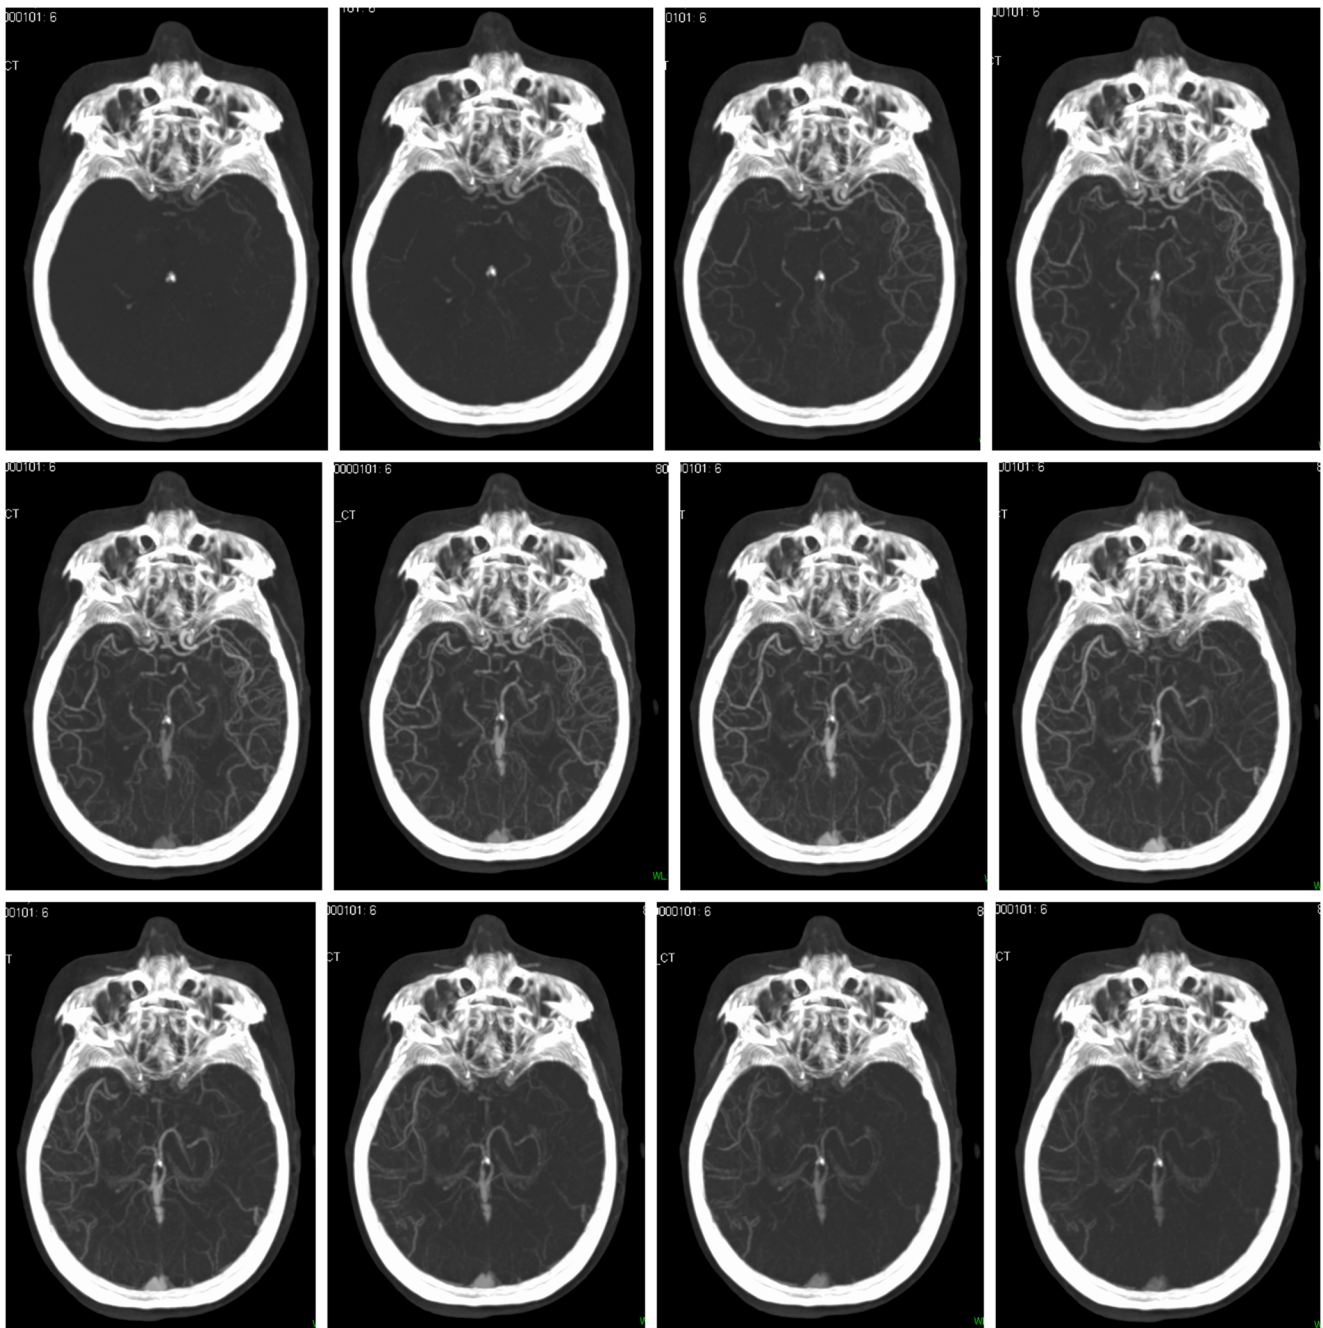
Four-dimensional CT angiograms including almost all bilateral MCAs and showing proximal occlusion of the right MCA with good collateral development
